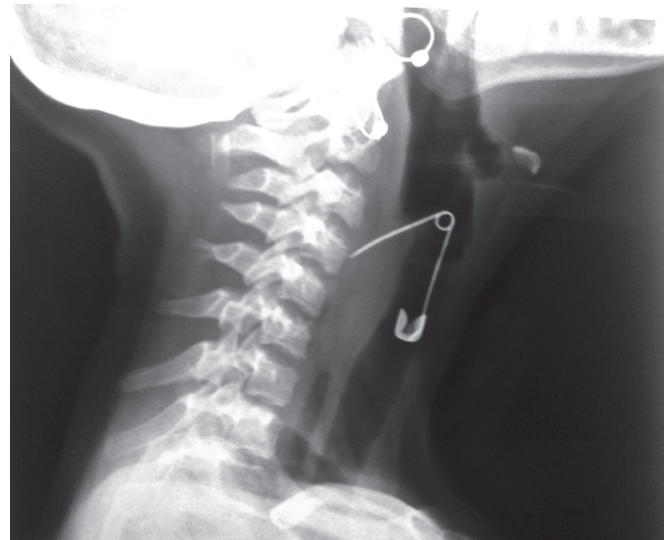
X-ray neck (lateral view) showing open safety pin
